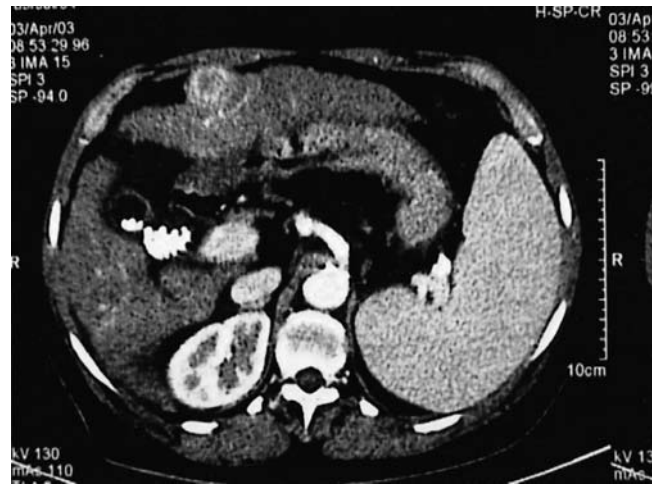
Helical computed tomography (CT) of exophytic HCC in segment III
